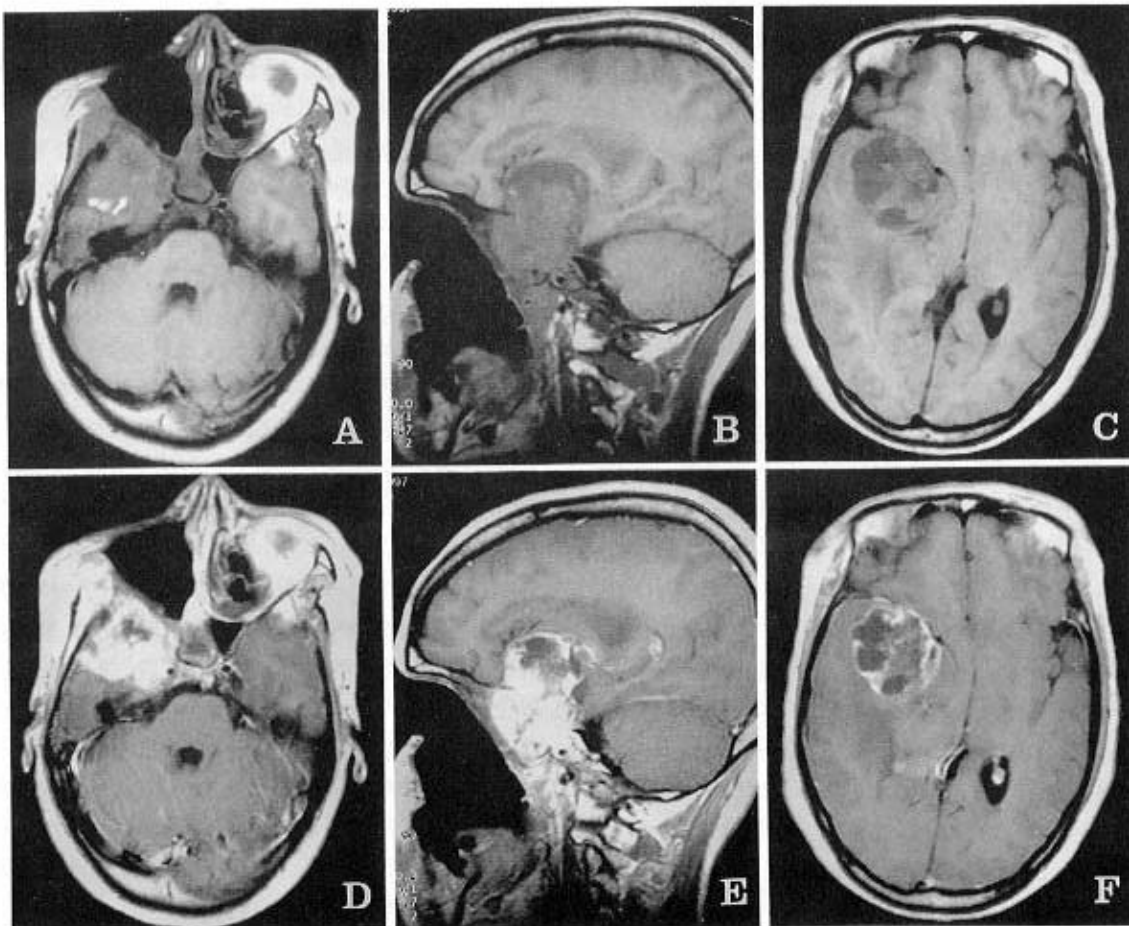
MRI scan without (A, B, C) and with (D, E, F) contrast. Highly enhanced mass in the right temporal base is seen. Surrounding peritumoral edema was also seen. The mass invaded the temporal bone, sphenoid sinus and sphenoid bone.
